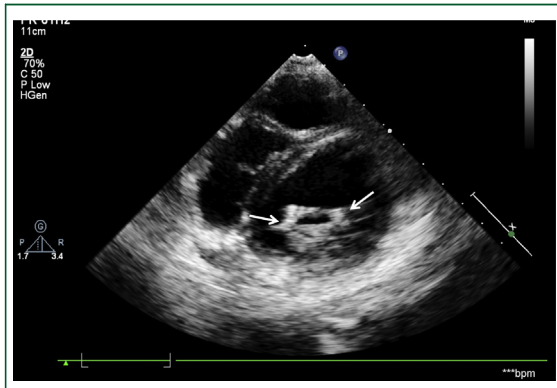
Parasternal short-axis view showing severe mitral stenosis with commissural fusion (arrows).
